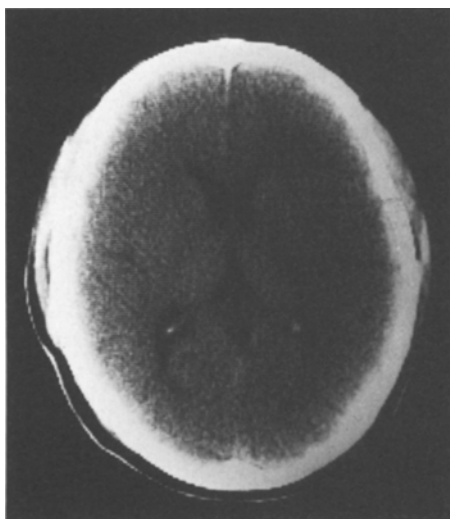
CT scan of a control case showing no abnormality
